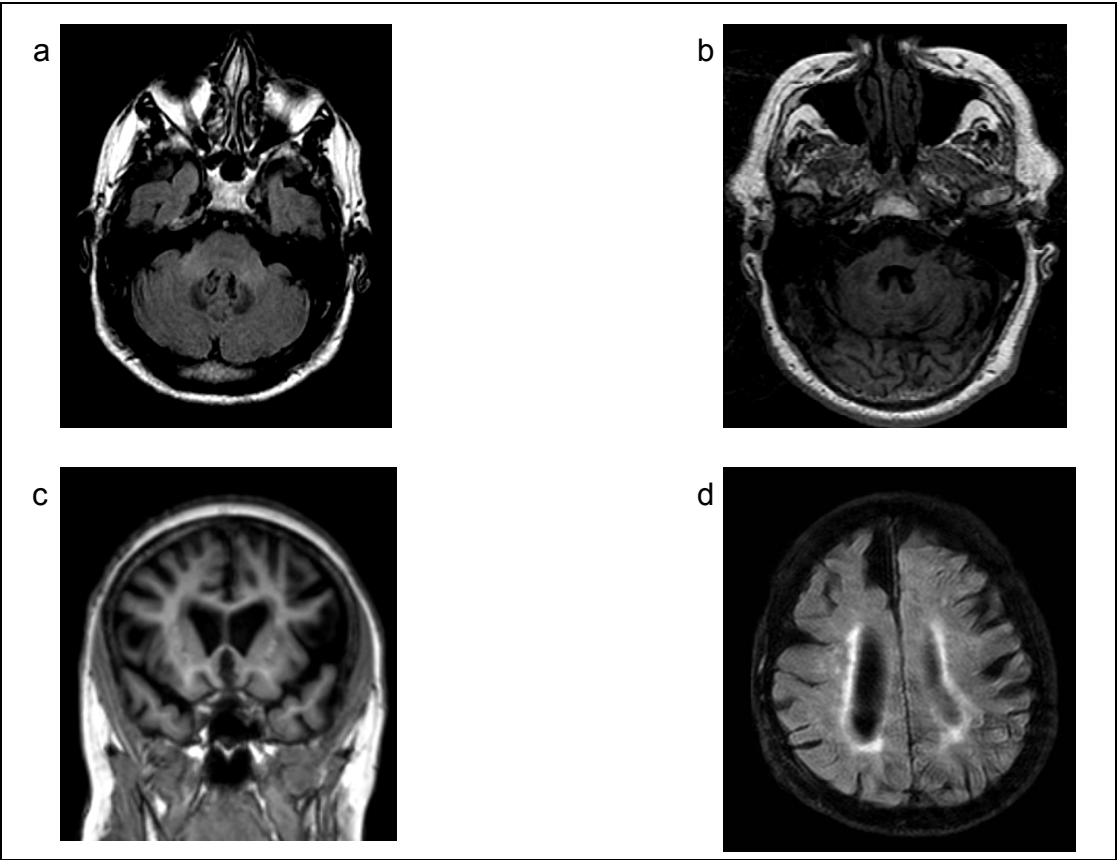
MR images showing characteristic findings in FXTAS. 1a. Axial FLAIR- MCP sign (middle cerebellar peduncle hyperintensities); 1b. Axial T1- Cerebellar and pontine atrophy; 1c. Coronal T1- Cerebral atrophy; 1d. Axial FLAIR- Hyperintensities in the cerebral white matter.
